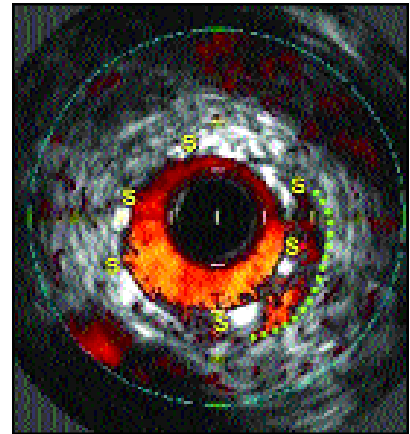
Intravascular ultrasound (IVUS). IVUS with colour enhancement was done after stenting this coronary artery. This snapshot of the cross-section of the coronary artery shows the US catheter (1 mm diameter) in the centre (black), the echodense (white) struts (S) of the stent and the lumen of the vessel. Inadequate expansion of the stent is shown — a gap is noted between the struts and the edge of the lumen (green dotted line). Further high-pressure balloon inflation to optimise stent deployment is indicated.
